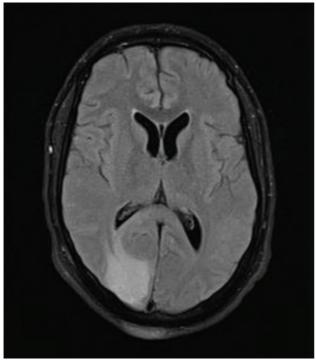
T2 FLAIR magnetic resonance image showing hyperintensity in right occipital region.
